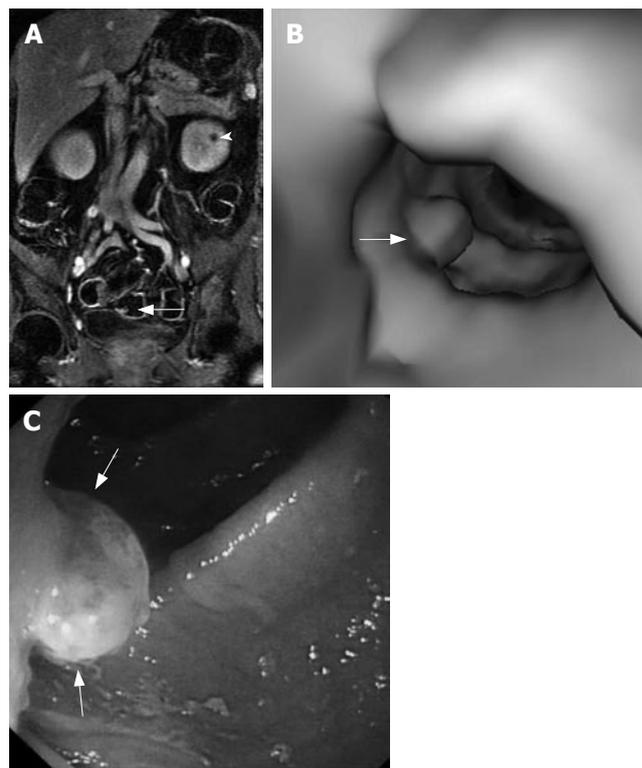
54-year-old man with positive results of FOBT. A: Coronal gadolinium enhanced T1-weighted image shows a 7 mm polyp (white arrow) in the sigmoid colon and a cyst (white arrowhead) in the left kidney; B: Virtual endoscopic rendering shows a well-defined filling defect (white arrow) in the sigmoid colon; C: Endoscopy confirms the polyp (white arrows).
